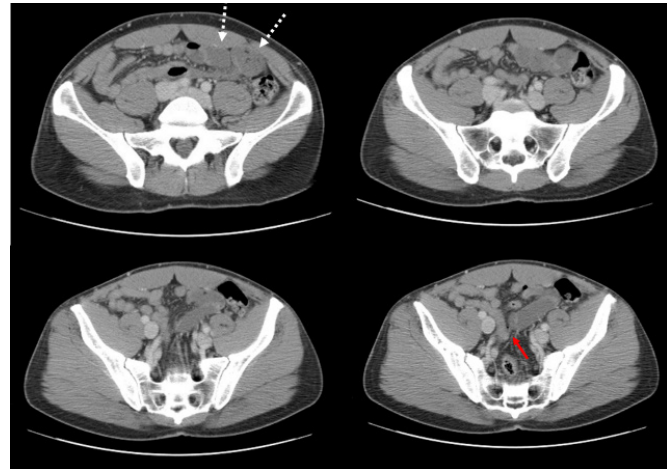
Axial images from computed tomography scan of the abdomen and pelvis with IV contrast showing dilated loops of small bowel (dashed white arrows) and suspected transition point (solid red arrow).
